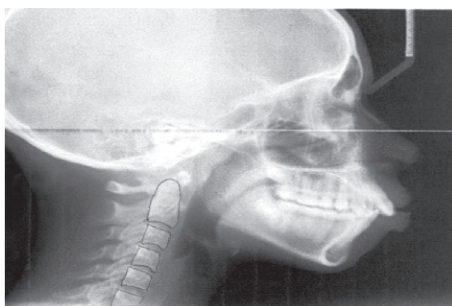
Cephalometric radiograph showing the 2nd to 6th cervical vertebrae
